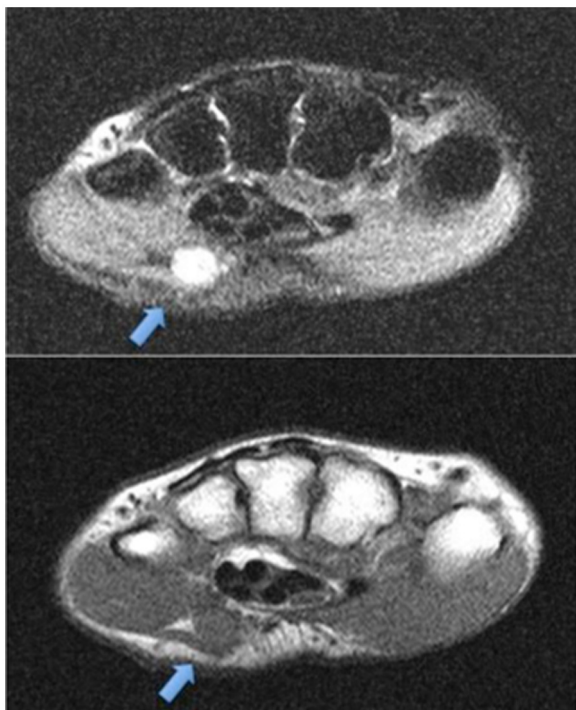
Preoperative MRI displayed an intraneural ganglion cyst related to the ulnar nerve.
